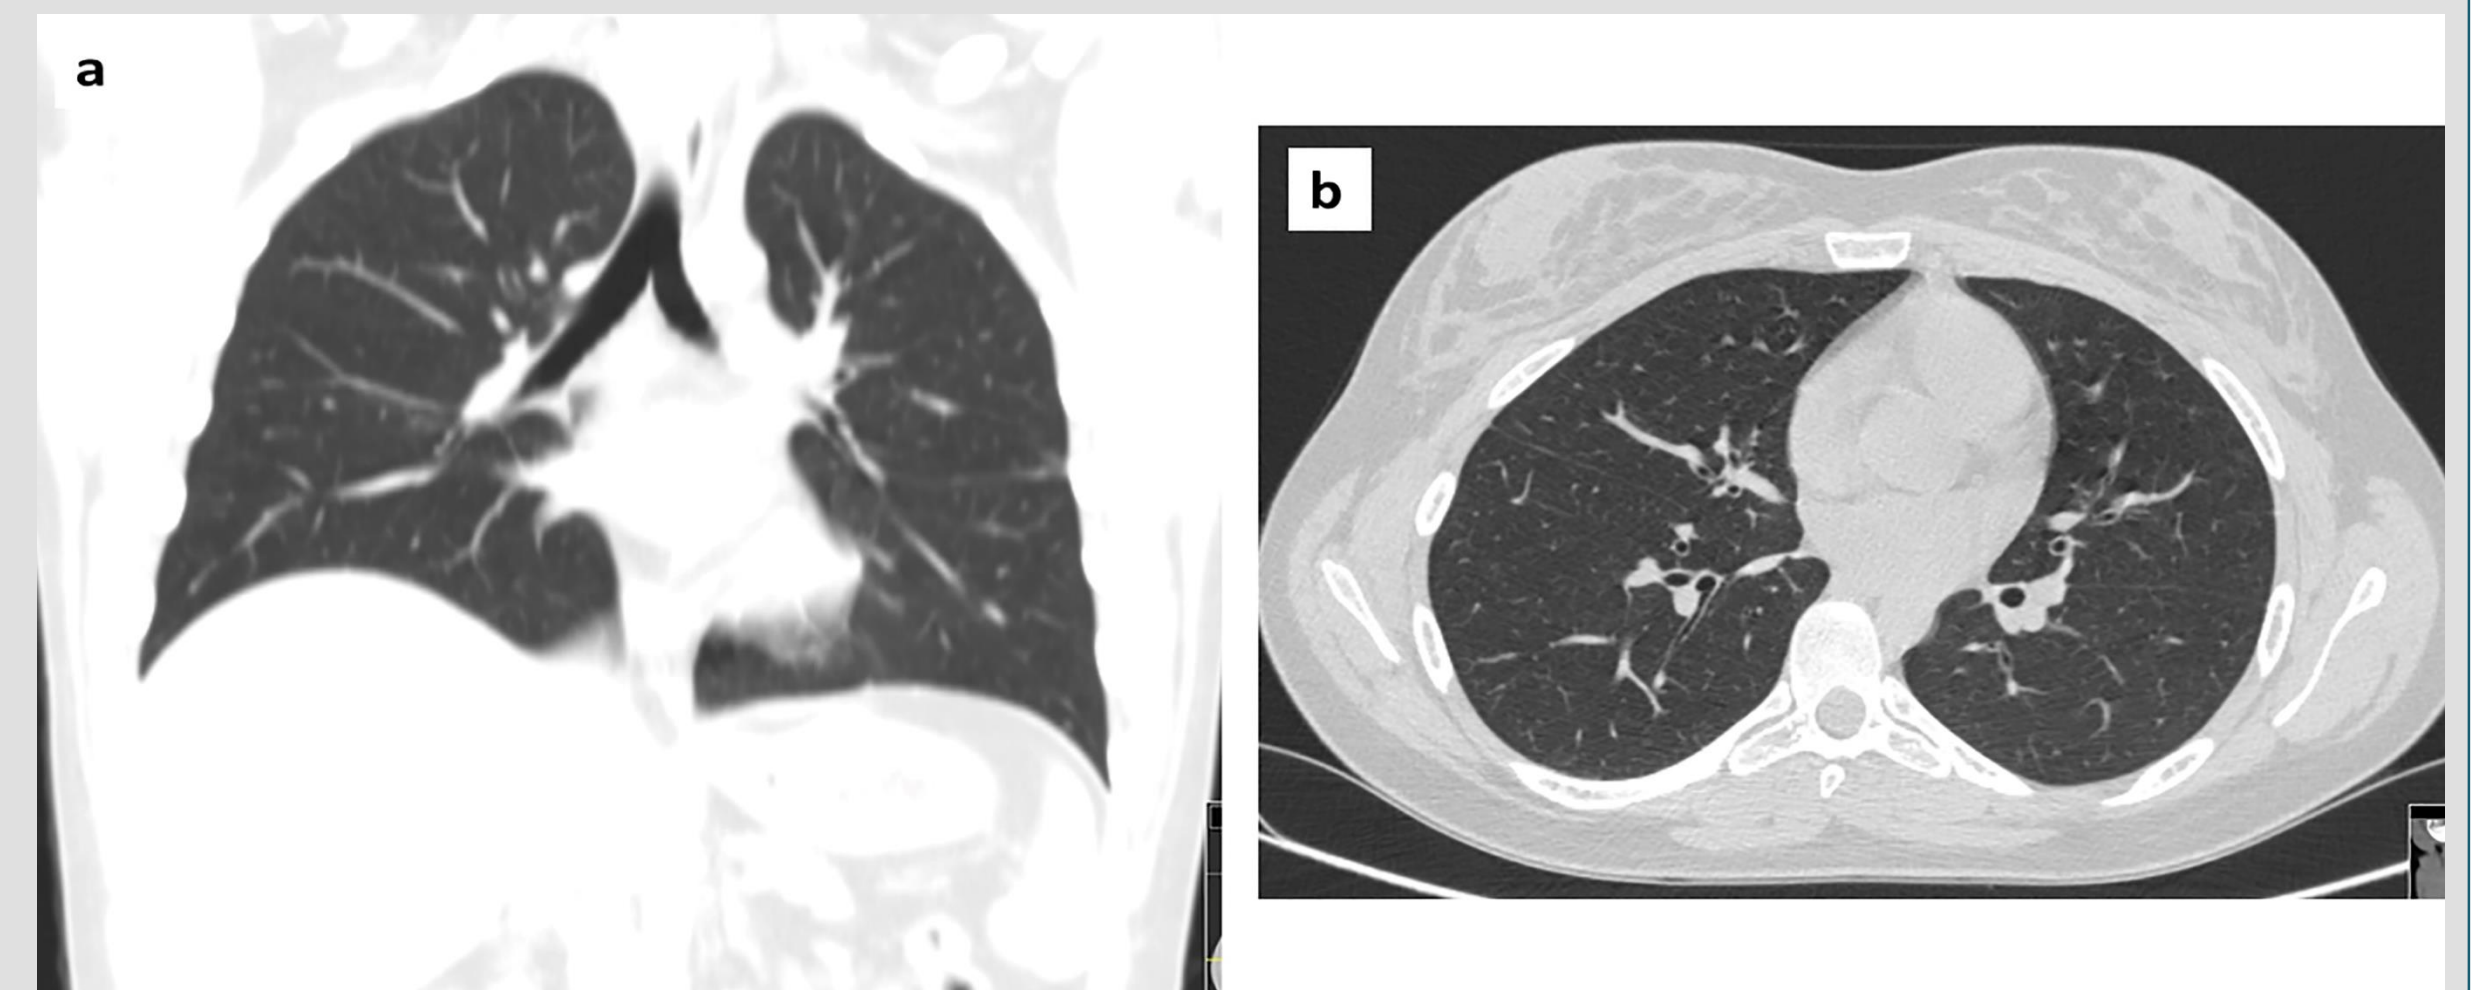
Thorax CT scan images in coronal (a) and axial (b) views showing complete resolution of lung abnormalities.
